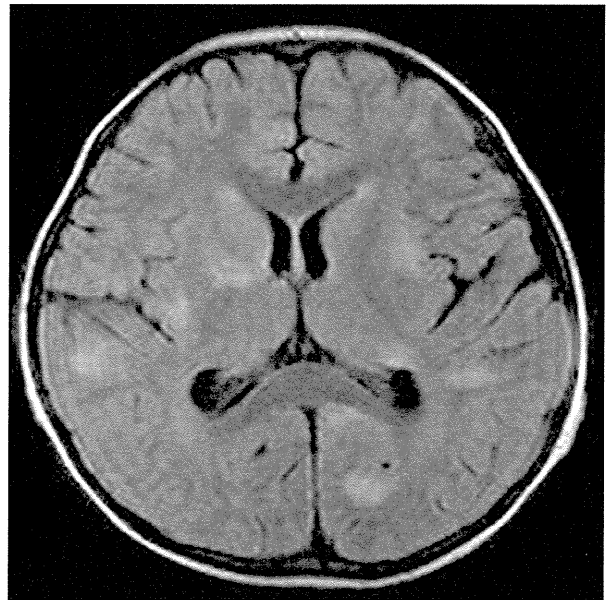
Axial T2-weighted MRI of the patient's brain. Several high intensity signals are observed in the brain, as indicated
